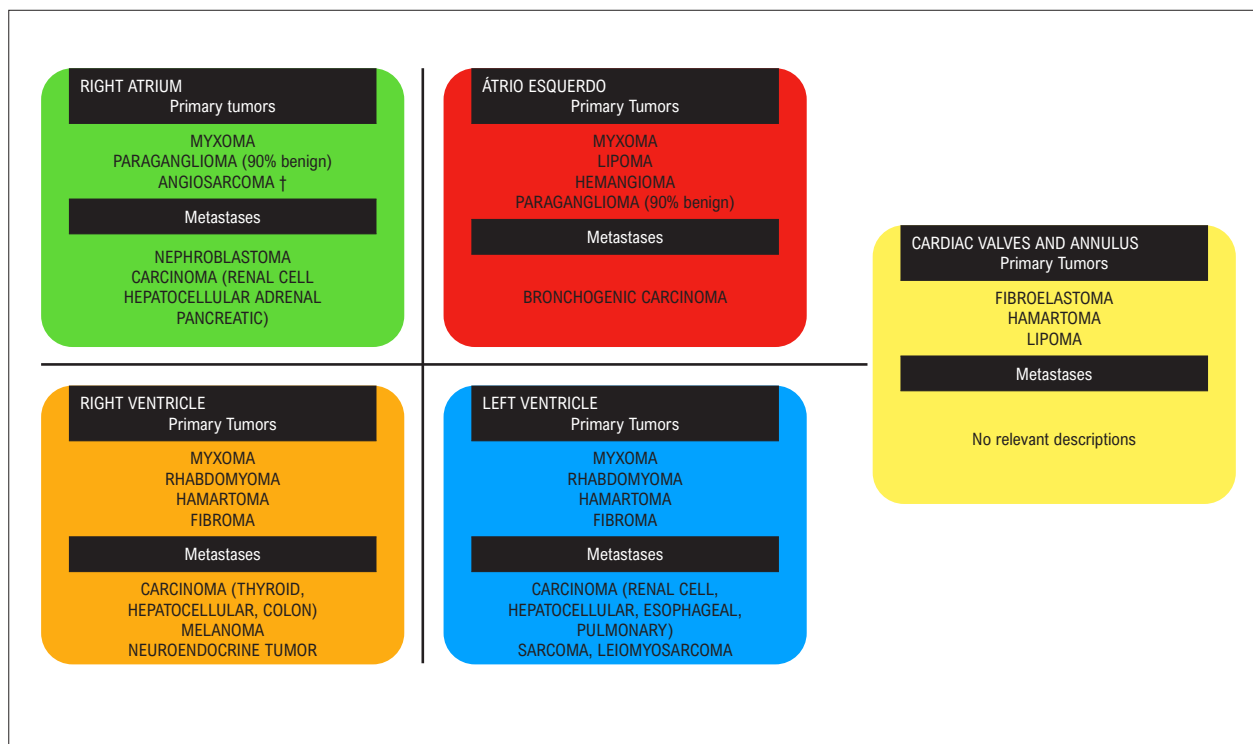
Specific location of the main obstructive cardiac tumors detected on transthoracic echocardiogram. Adapted from Griborio Guzman AG et al. † Malignant characteristic.
